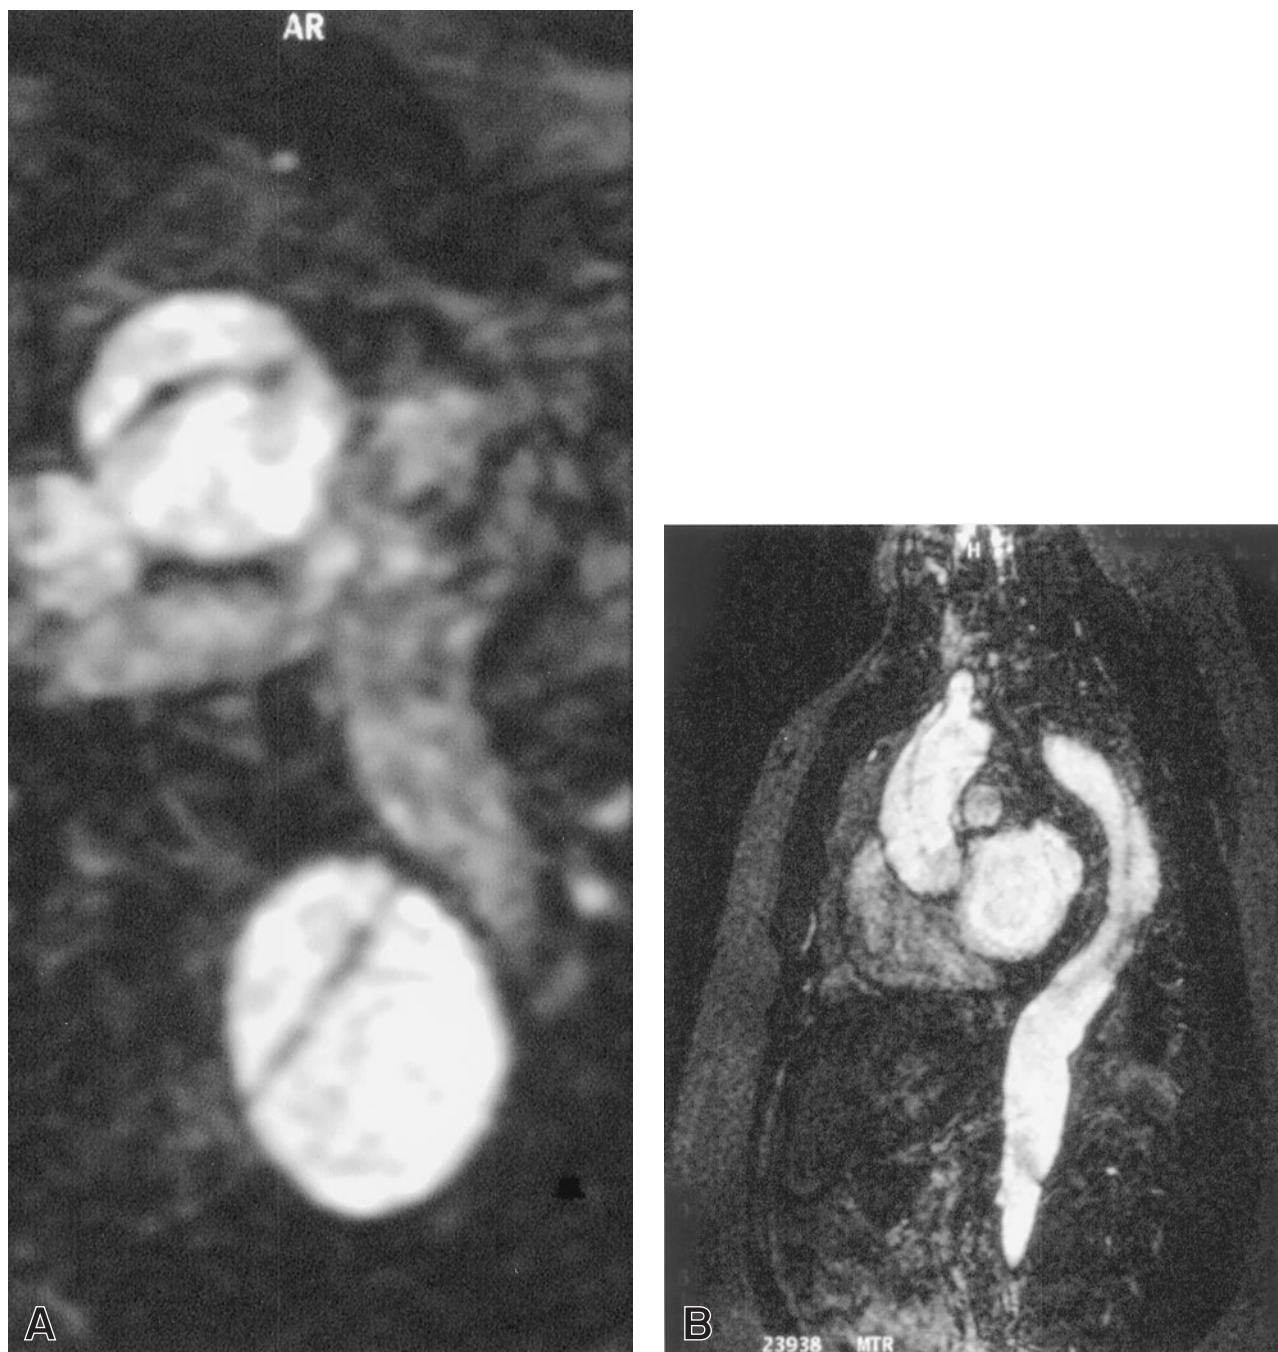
Axial (A) and sagittal (B) contrast-enhanced magnetic resonance images of a chronic type A dissection.
